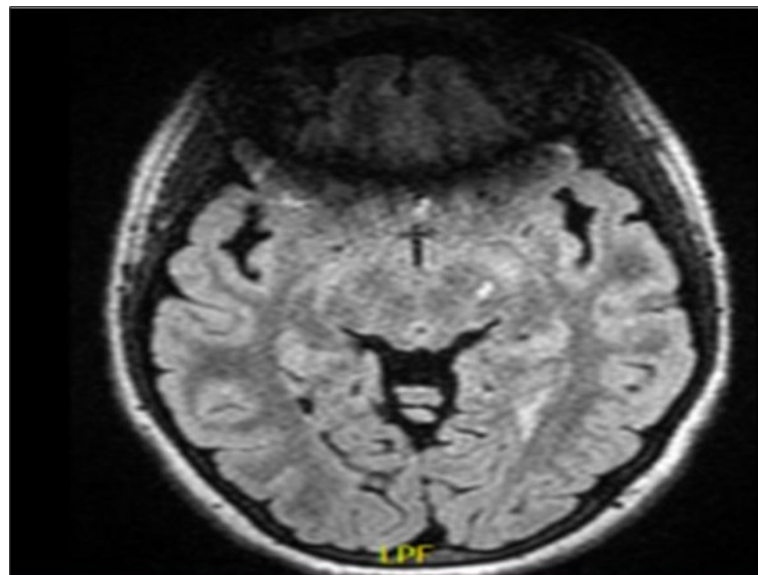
showing a left midbrain demyelinating lesion on a fluid attenuated inversion recovery (FLAIR) image. To note, there is an artifact anteriorly because of the presence of teeth orthodontics.
